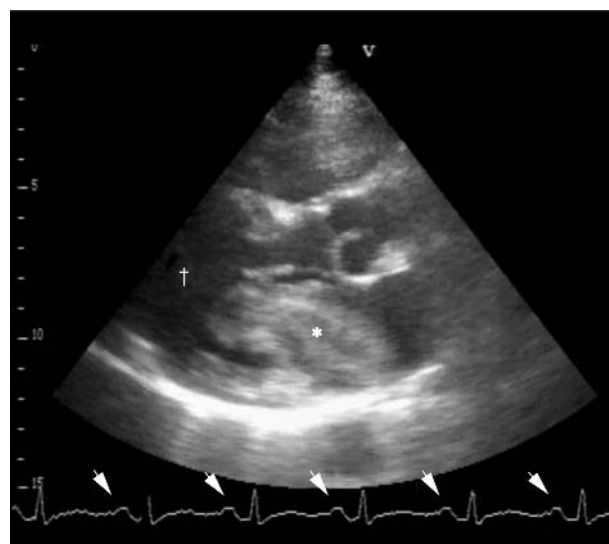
Echocardiogram showing some details as in fig 1; although the left atrium is almost completely occupied by the myxoma, the patient is still in sinus rhythm (arrowheads).
